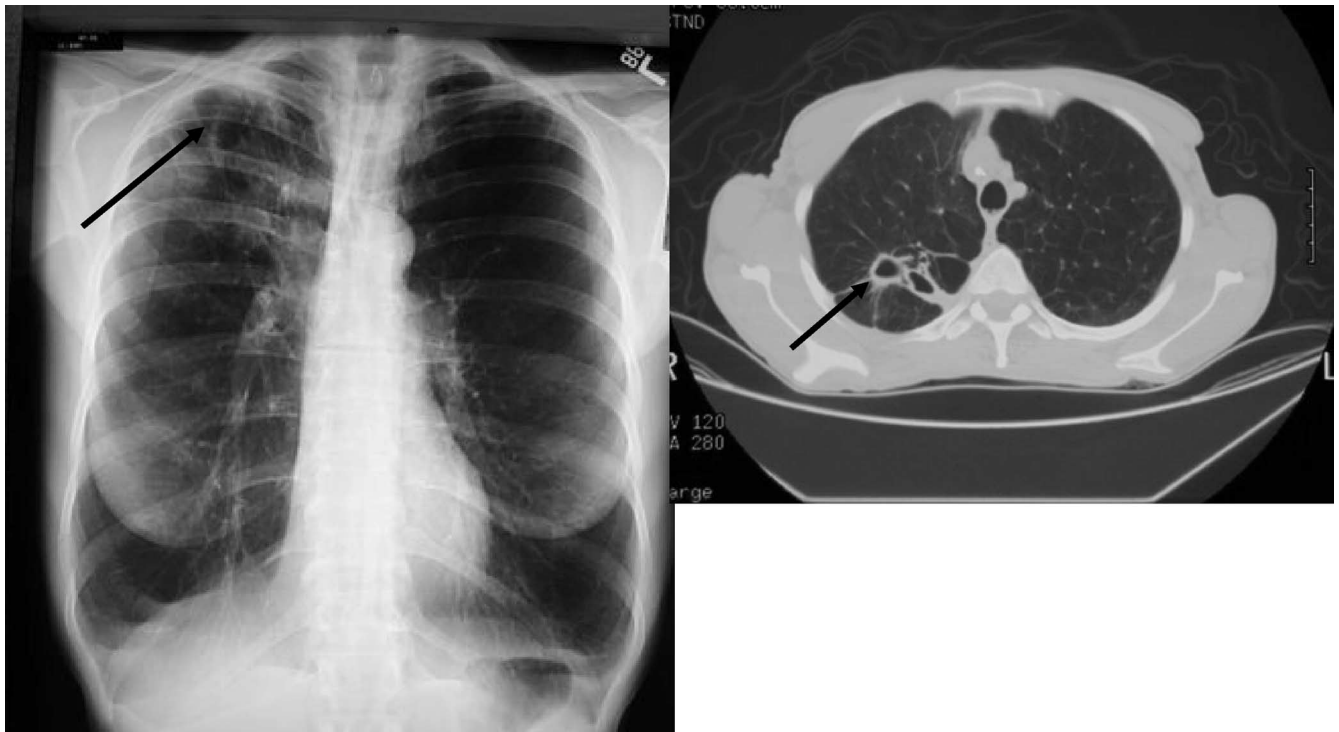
Mycobacterium avium* complex of the fibrocavitary type in a 52-year-old woman with chronic obstructive pulmonary disease visualized by plain radiography (left) and computed tomography (right).
